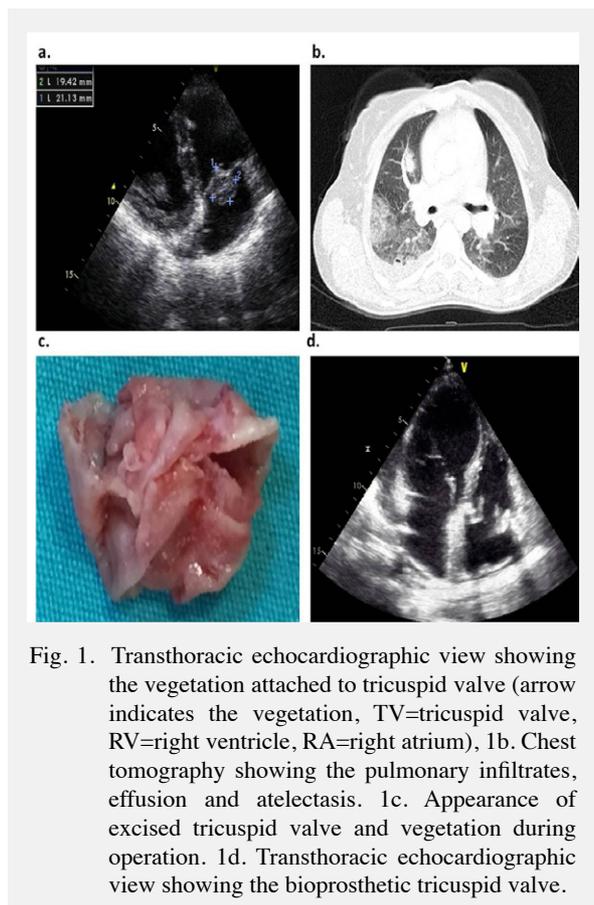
Transthoracic echocardiographic view showing the vegetation attached to tricuspid valve (arrow indicates the vegetation, TV=tricuspid valve, RV=right ventricle, RA=right atrium), 1b. Chest tomography showing the pulmonary infiltrates, effusion and atelectasis. 1c. Appearance of excised tricuspid valve and vegetation during operation. 1d. Transthoracic echocardiographic view showing the bioprosthetic tricuspid valve.
